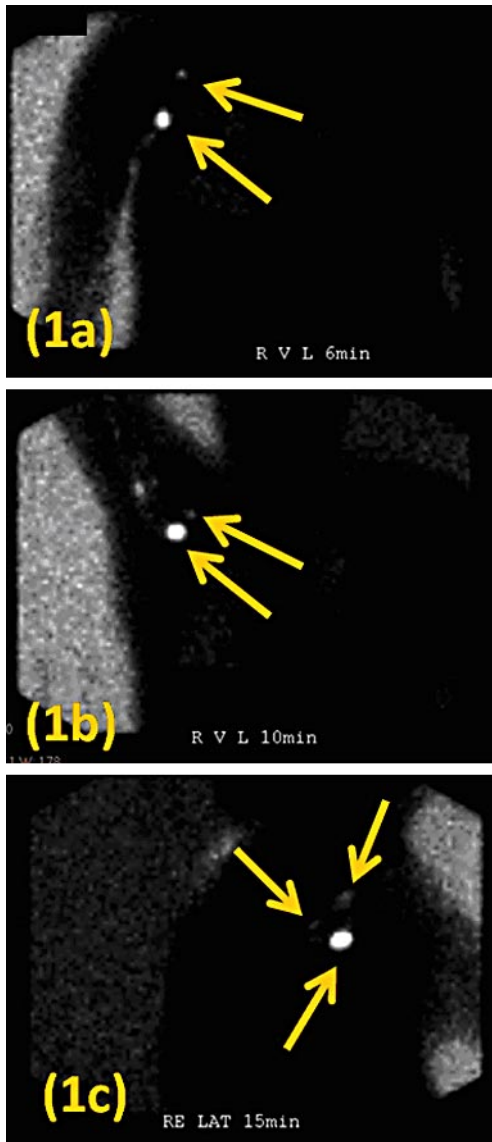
Preoperative dynamic scintigraphy showing 3 axillary nodes: a Anteroposterior image 6 min after injection with arm in lower position, b anteroposterior image 10 min after injection with arm in upper position, c lateral image 15 min after injection.
